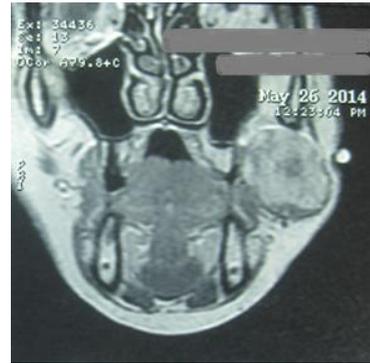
Coronal T2-Weighted MRI; showing a well-defined and circular mass in deep part of left buccal area just anterior to masseter. This mass showing moderate and in homogenous contrast enhancement
